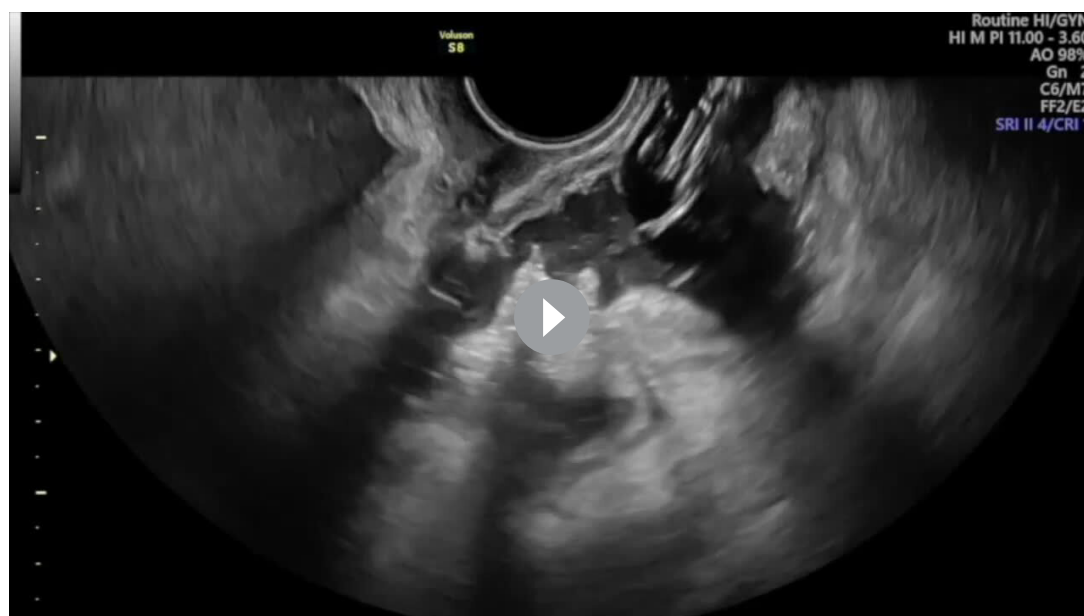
Normal ultrasound view of colorectal anastomosis.
